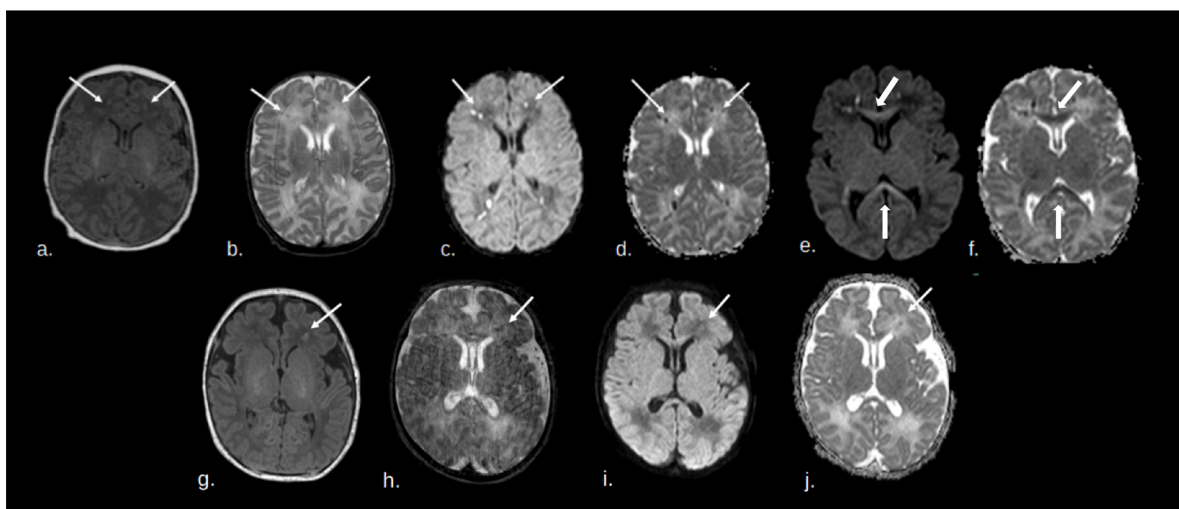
Brain MRI imaging of 2 neonates with HPeV infection. a-f) Neonate with multiple bilateral punctate lesions in the periventricular white matter that appear a) hyperintense in axial T1-weighted image, b) hypointense in T2-weighted image, c) with high signal on DWI and d) with low signal on ADC sequences; in the same patient, corpus callosum lesions with e) high signal on DWI and f) low signal on ADC sequences coexisted. g-j) Neonate with isolated unilateral punctate lesion in the periventricular white matter that appear a) hyperintense in axial T1-weighted image, b) hypointense in T2-weighted image, c) with high signal on DWI and d) with low signal on ADC sequences. DWI: diffusion weighted imaging. ADC: apparent diffusion coefficient of water.
